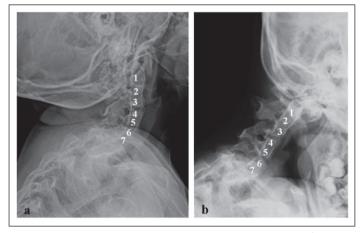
Laterals cervical radiographies (a y b) showing sinostosis of vertebral bodies C1-2-3, C4-5 and C6-7. a) Extension. b) Flexion.
